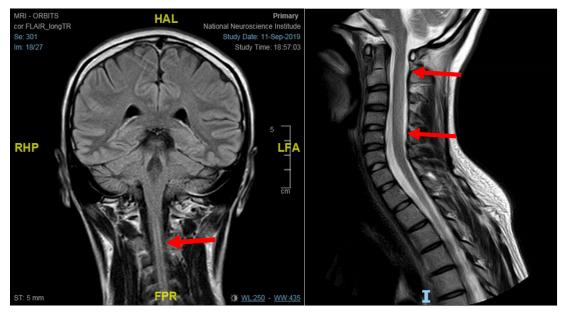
B, C. Coronal FLAIR and Sagittal T2W MRI showing linear hyperintense signal in (arrows) the cord extending from C2-C5 vertebral levels predominantly in the posterior aspect of the cord with mild swelling.
